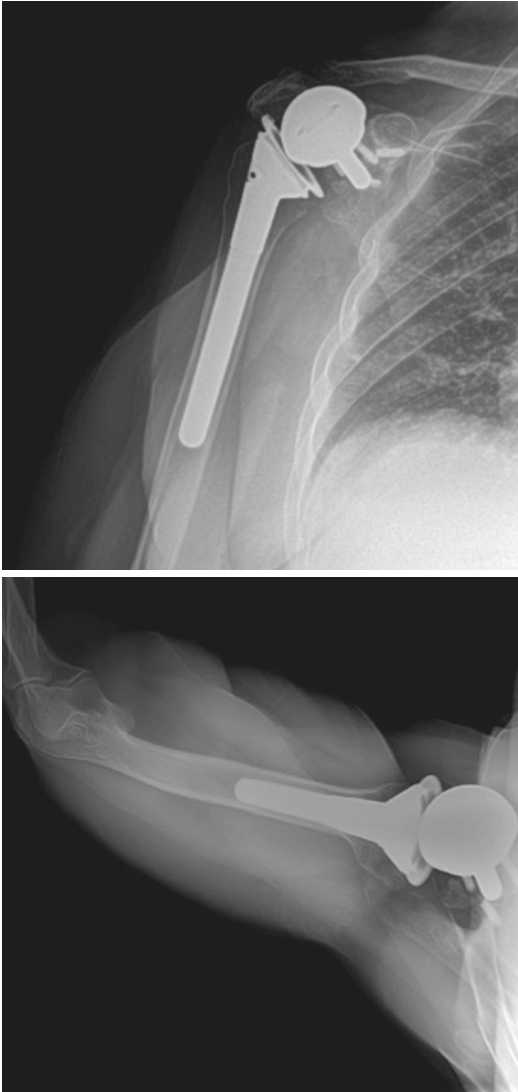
78-year-old male who presented 1 year after pain and stiffness following reverse total shoulder arthroplasty with AP and axillary X-ray revealing a failed baseplate due to aseptic loosening
